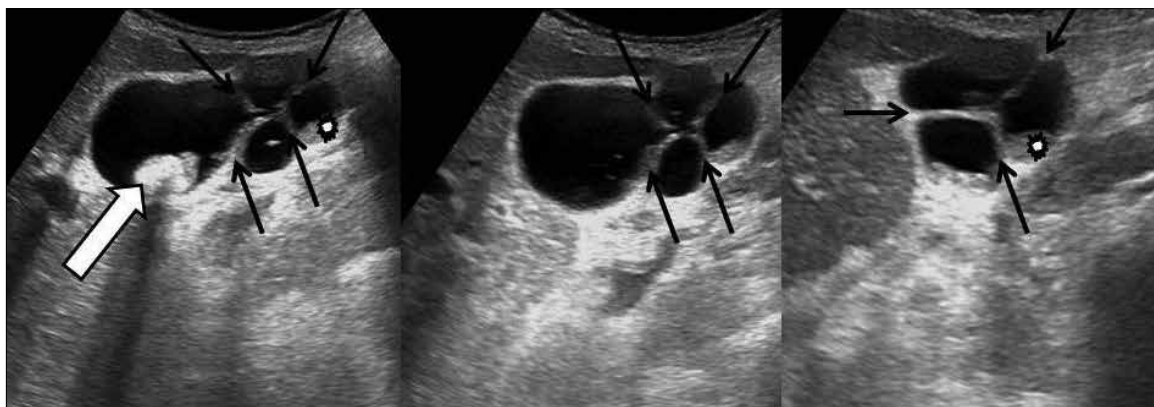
Transabdominal sonography showed multiple septa with a honeycomb appearance (black arrows), gallstones (wide arrow), and sludge (star shape) within the honeycomb appearance
